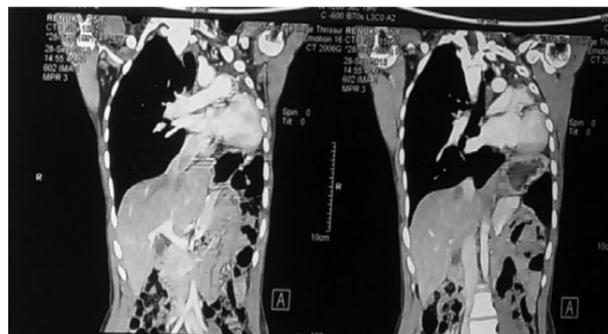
CT thorax absent left pulmonary artery and lung, Herniation of right lung through posterior part, Elevated diaphragm
